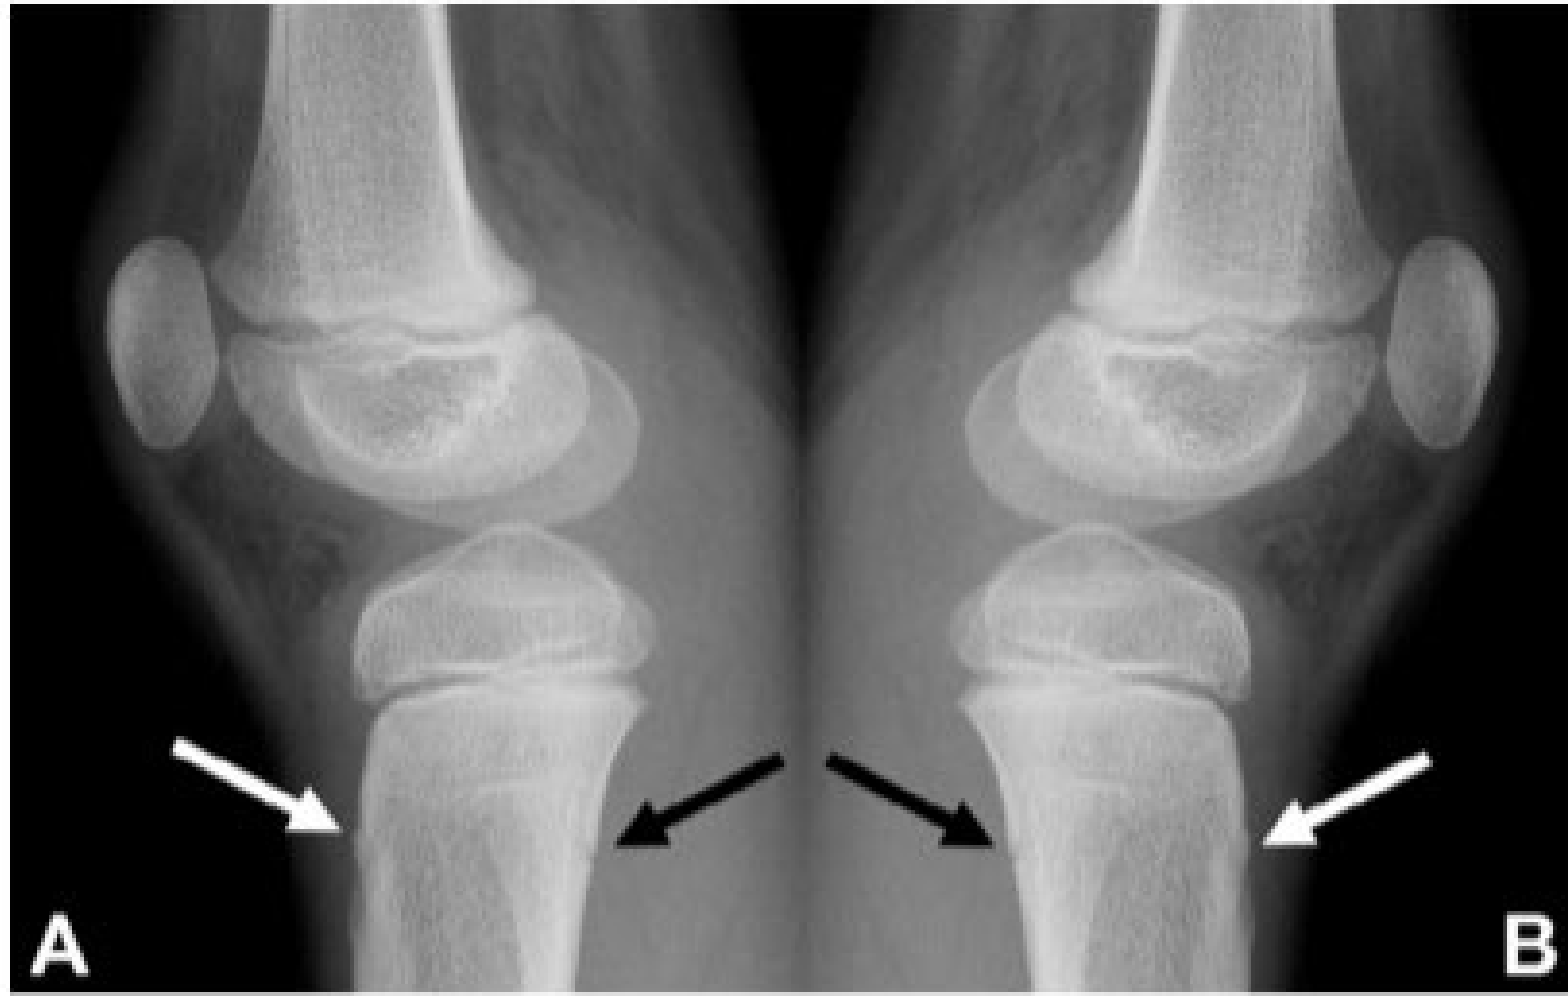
Baseline lateral radiographs of the right (A) and the left (B) knees show bilateral buckling of the upper anterior tibial cortex (white arrows) and a bilateral cortical breach at the upper posterior tibia (black arrows).
